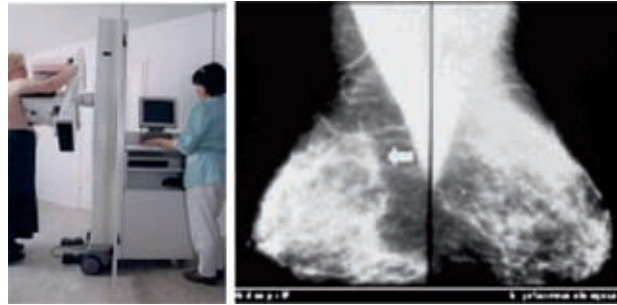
An image produced using modern methods of X-ray intensity measurement and computer-aided imaging (left) compared with an image of the same organ (female breast) recorded on a traditional plate
